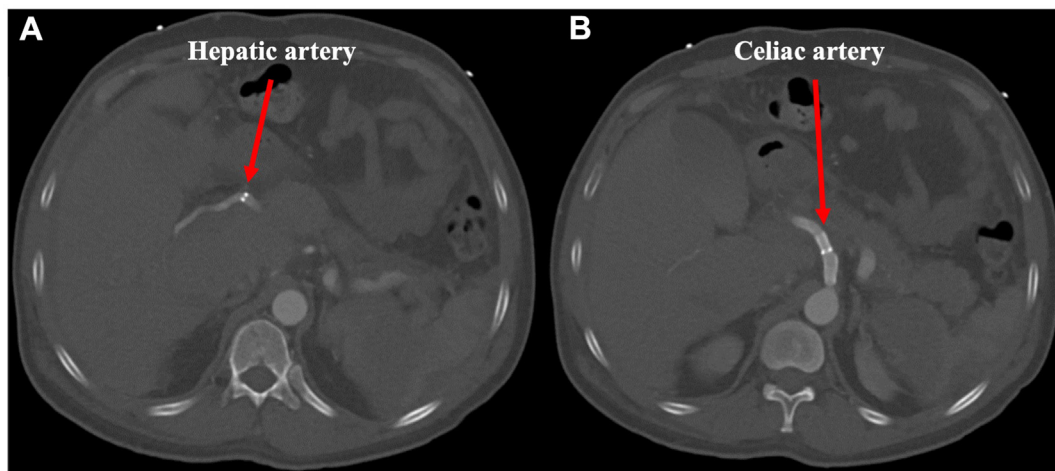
Computed tomography (CT) scan at discharge noting patent hepatic (A) and celiac (B) artery stents.
